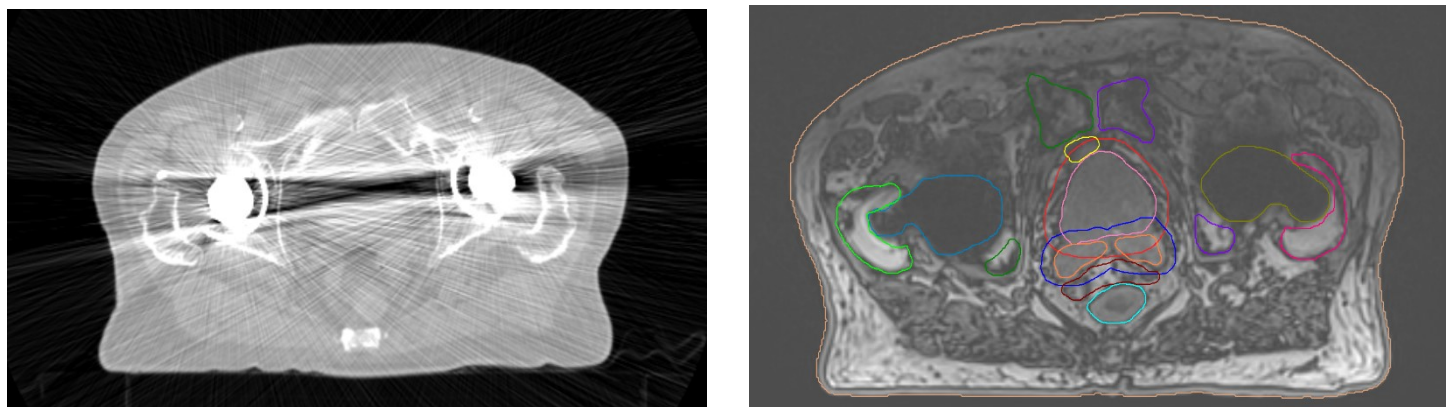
Comparison between CT images (on the left), characterized by relevant artifacts, and MRI ones, used to generate the sCT for the treatment plan.
